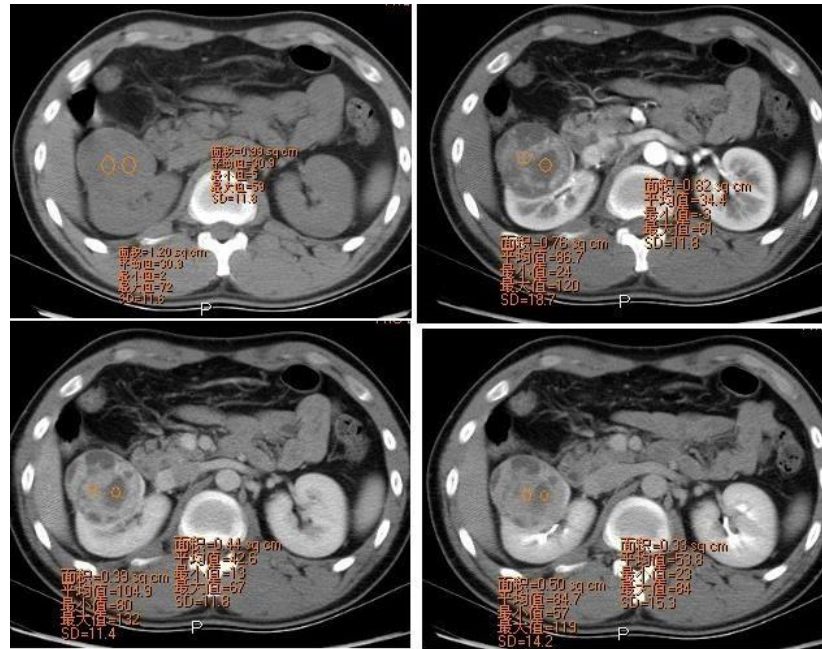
Male, 24 years, right renal papillary carcinoma;(A).In unenhanced phase there is homogeneous round mass with clear boundary in the upper pole of the right kidney with CT value of 30HU;(B).In corticomedullary phase mass is heterogeneous and mildly enhanced by the mass with CT value of 86HU;(C).the CT value of same location is 104HU in the parenchymal phase ;(D).in excretion phase the CT value is84HU.
